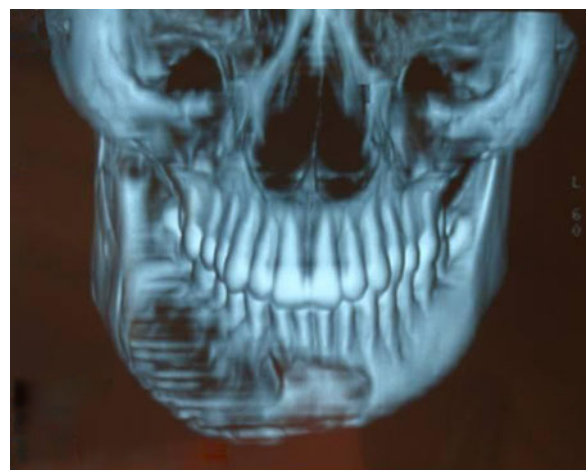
Preoperative 3D-CT scan
